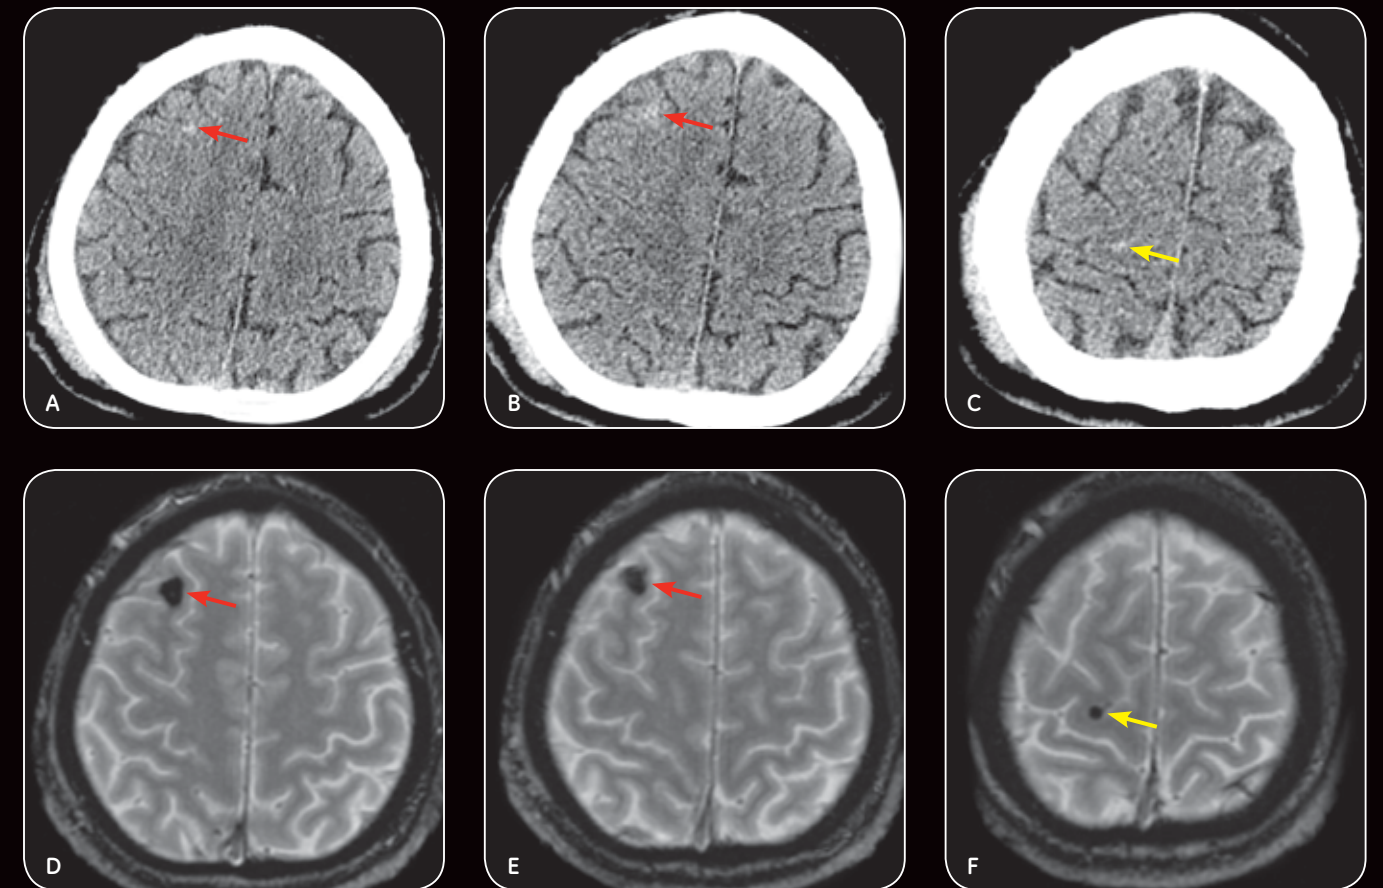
On the CT images (A-C), neuroradiologist interpreted two areas of subtle high density in right frontal sulci (red and yellow arrows) as subarachnoid hemorrhage. No other abnormal CT findings were present. However, T2*-weighted gradient echo (D-F) indicates subcortical hemorrhages signifying traumatic axonal injury involving the right middle frontal gyrus (red arrows) and right motor gyrus (yellow arrow).
